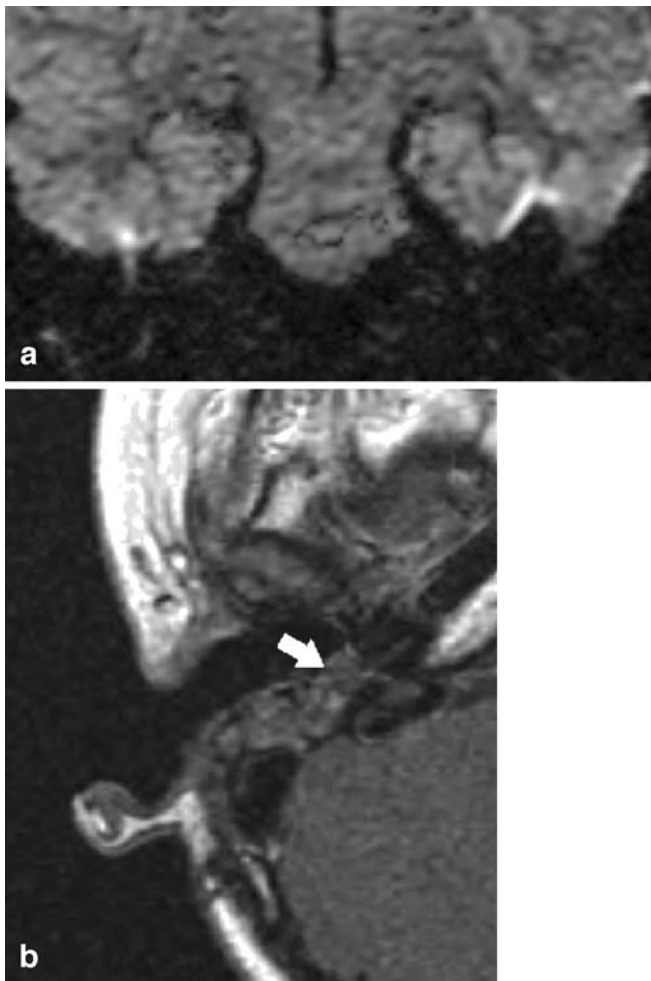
a A 10-year-old boy suspected of having a primary acquired cholesteatoma. Previous MR imaging shows a large curvilinear artefact under the tegmen and middle fossa on both sides on echo-planar DWI. A clear hyperintensity, suggestive for a cholesteatoma was not seen on echo-planar DWI. b Same patient as in a. Note the hypointense non-enhancing nodular lesion in the retrotympa- num on axial contrast-enhanced T1-weighted images suggestive of a cholesteatoma (*arrow*). Surgery revealed the presence of a cholesteato- ma in the retrotympa- num with a diameter of 5 mm
